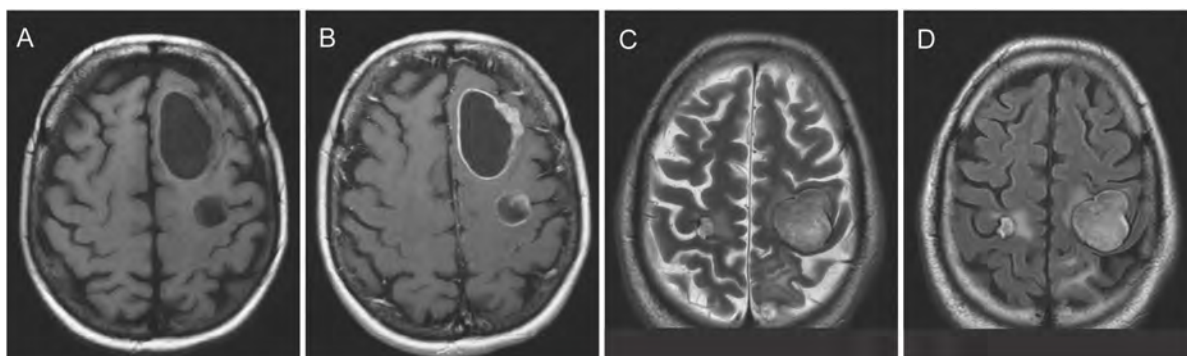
Radiographical assessment of brain metastases. A, B: Axial T₁ weighted MRI scans with (B) and without (A) contrast agent of a patient with brain metastatic lung cancer. The lesions had a cystic appearance with ring-enhancing contrast agent effect (B) (case courtesy of Prof F Gaillard, Radiopaedia.org, rID: 3972). C, D: Axial T₂ (C) and FLAIR (D) scans of a 60-year-old man with brain metastasis from colorectal cancer (case courtesy of Dr M Shebl, Radiopaedia.org, rID: 19894).
